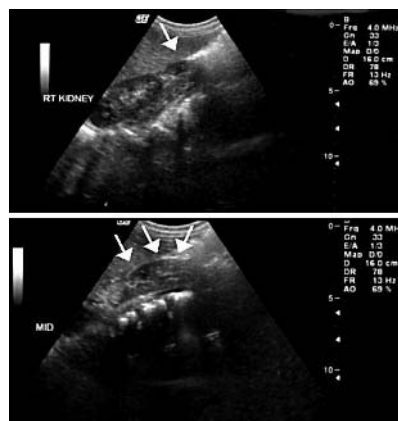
Renal ultrasound showed a mass extending over the midline compatible with the diagnosis of a crossed fused ectopic left kidney.
